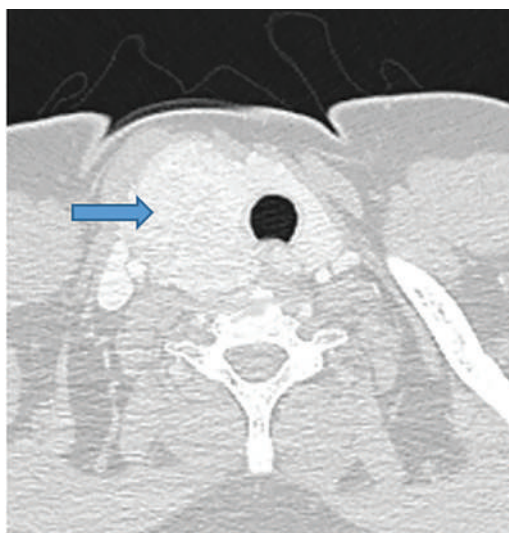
A 10 cm metastatic mass causing tracheal compression and deviation (axial CT scan).
